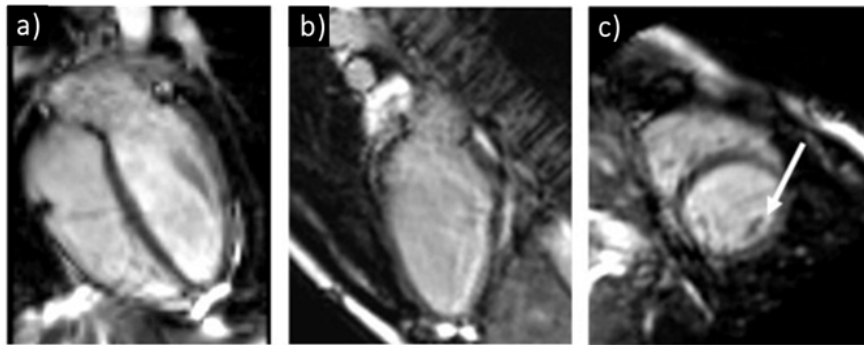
CINE-MRI images of a volunteer in diastole showing the a) 2-chamber b) 4-chamber c) short-axis (SA) view of the ventricles (where the arrow indicates the papillary muscles). Image adapted from [25].
